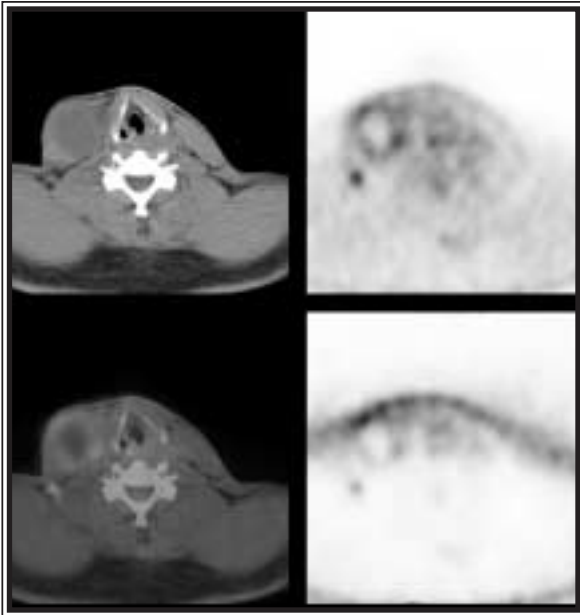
A cystic mass in the neck clinically diagnosed elsewhere as a benign cyst. Integrated PET/CT shows intense FDG uptake in perimeter of mass with a photopenic center. Subsequent surgery confirmed this lesion to be a metastatic lymph node from a very small tonsil cancer.
